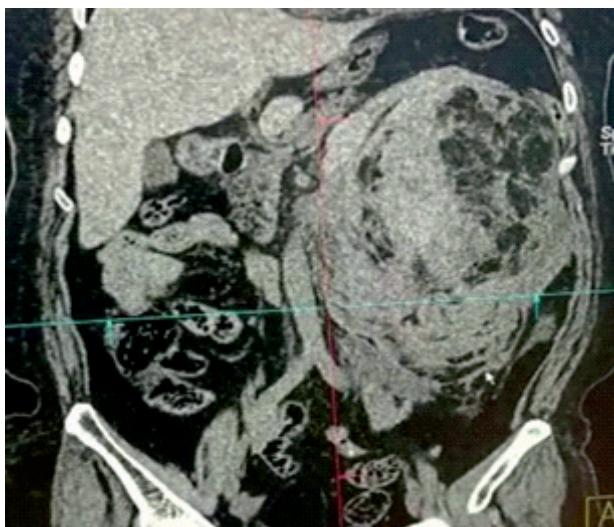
CT scan: Retroperitoneal formation, 15x20 cm.
